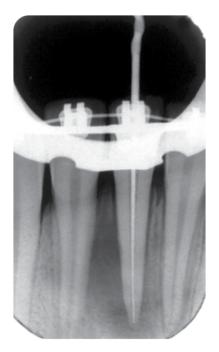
Working-length determination. (Radiograph courtesy of Dr. Domenico Ricucci).
